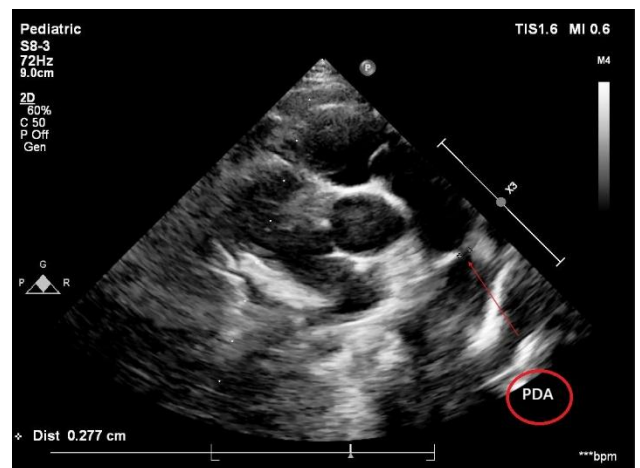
Transthoracic echocardiography (2D ECHO) showing a small (2 mm) patent ductus arteriosus (PDA).
